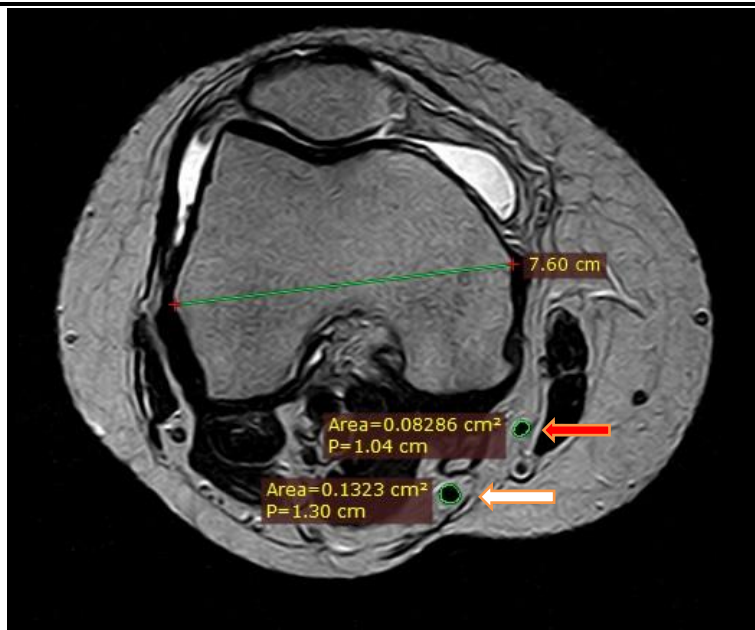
Measurement of semitendinosus (white arrow) and gracilis (red arrow) CSAs in MRI
